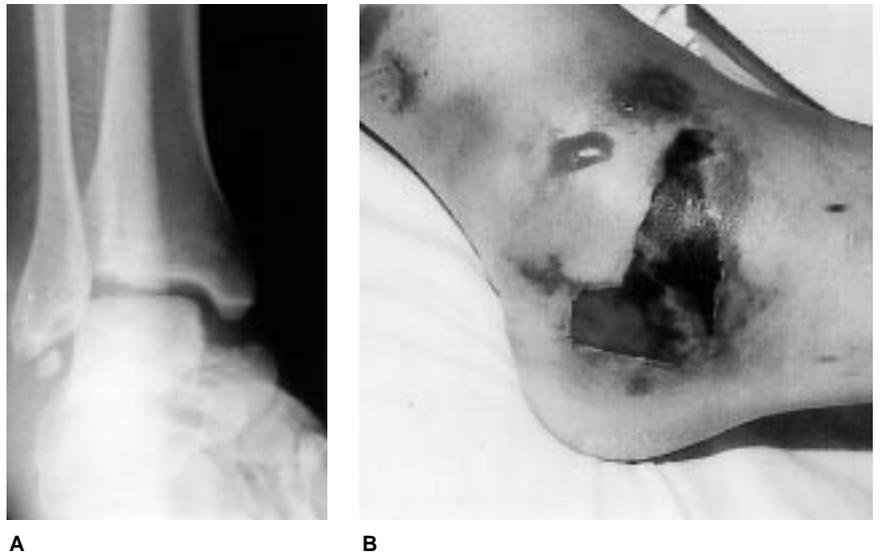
A, AP plain radiograph shows a Hawkins type III fracture. B, Injury was left unreduced for 48 hours, which resulted in full-thickness skin loss that necessitated free-vascularized-flap and skin-graft coverage.
